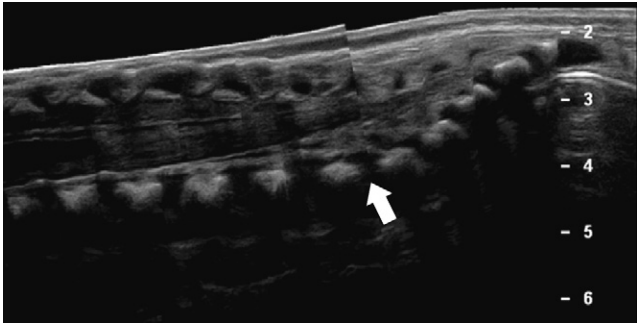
Infant spinal ultrasound. Longitudinal view of a normal lower spine/spinal canal in an infant. Note the two successive images are “stitched” together at the L5-S1 level (arrow) to create this panoramic view. The probe is placed on the lower back of the infant and oriented as to center the spinal canal. (From Beek E, Van Rijn R, ed. *Diagnostic Pediatric Ultrasound*. 1st ed. New York: Thieme; 2015)
